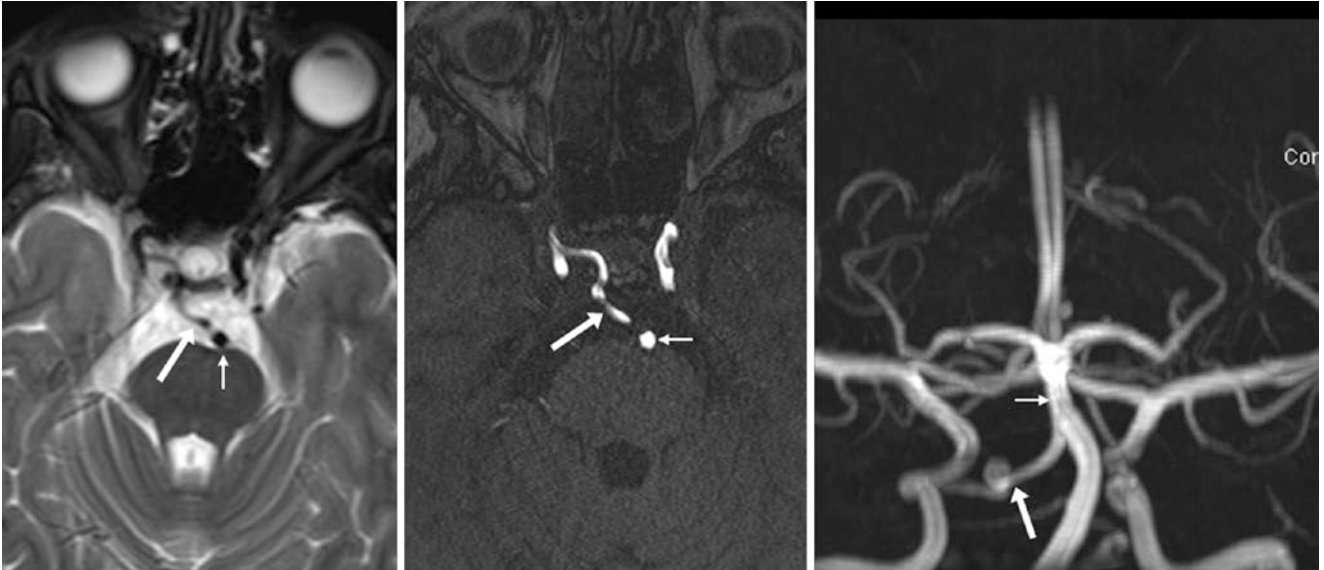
In this 19-year-old, an axial T2WI MRI (*left*) demonstrates a left PTA (*large arrow*) that travels from the cavernous ICA medially through the sella towards the mid-basilar (*thin arrow*). A 3D TOF MRA
